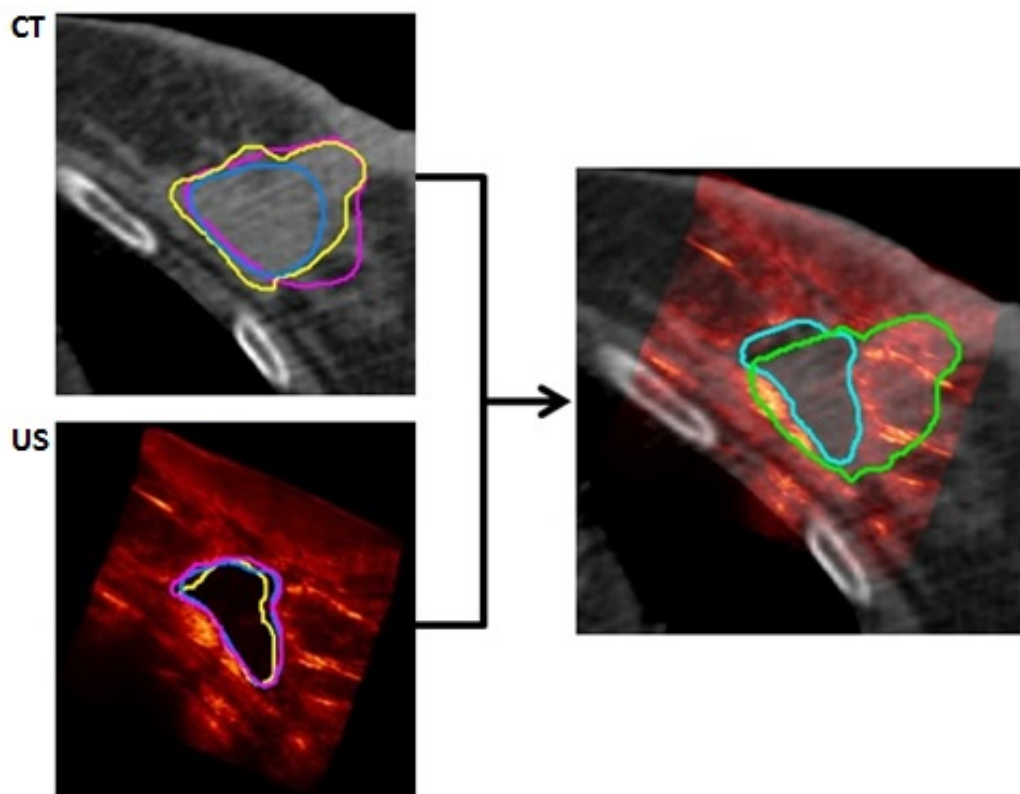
Seromas contoured by multiple users independently on CT and US (blue, purple, yellow) are used to create consensus volumes  $CTV_{CT}$  (cyan) and  $CTV_{US}$  (green), and fused using the implicit registration of the 3DUS system.
